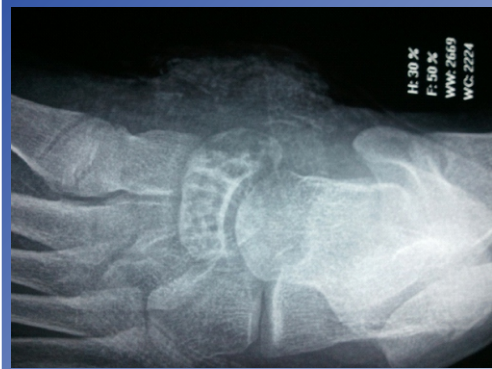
Pre-op X-ray: showing osteolytic lesion involving navicular bone with intact cortex
